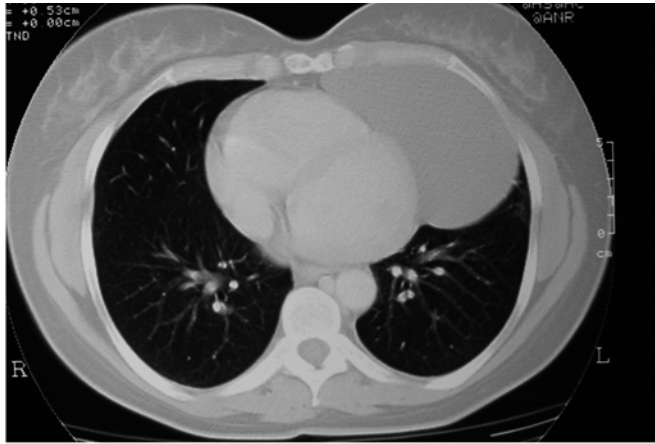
Computed tomographic scan image of giant left-sided pericardial cyst.
